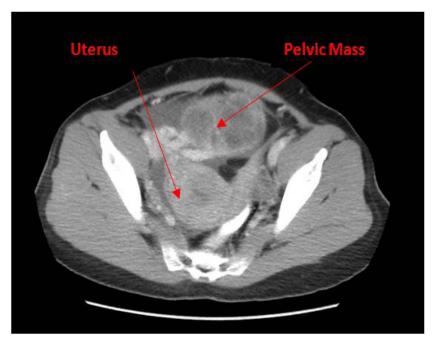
CT scan image. Post contrast axial image show a mass located in the pelvis, anterior to the uterus
